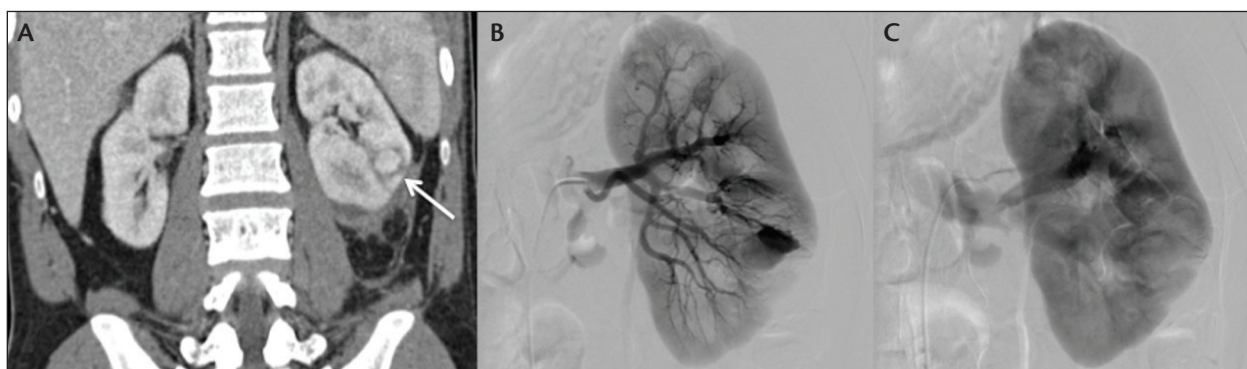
CT of the abdomen with coronal reconstruction showing a well-circumscribed lesion within the lower pole of the left kidney surrounded by hypodense parenchyma (white arrow; A). Catheter-based angiogram of the left kidney during late arterial phase confirming an oval-shaped lesion in the lower pole (B). Catheter-based angiogram of the left kidney during the venous phase, when the oval-shaped lesion is no longer visualized due to contrast washout (C). No increasing contrast blush is present, confirming the diagnosis of a pseudoaneurysm.
